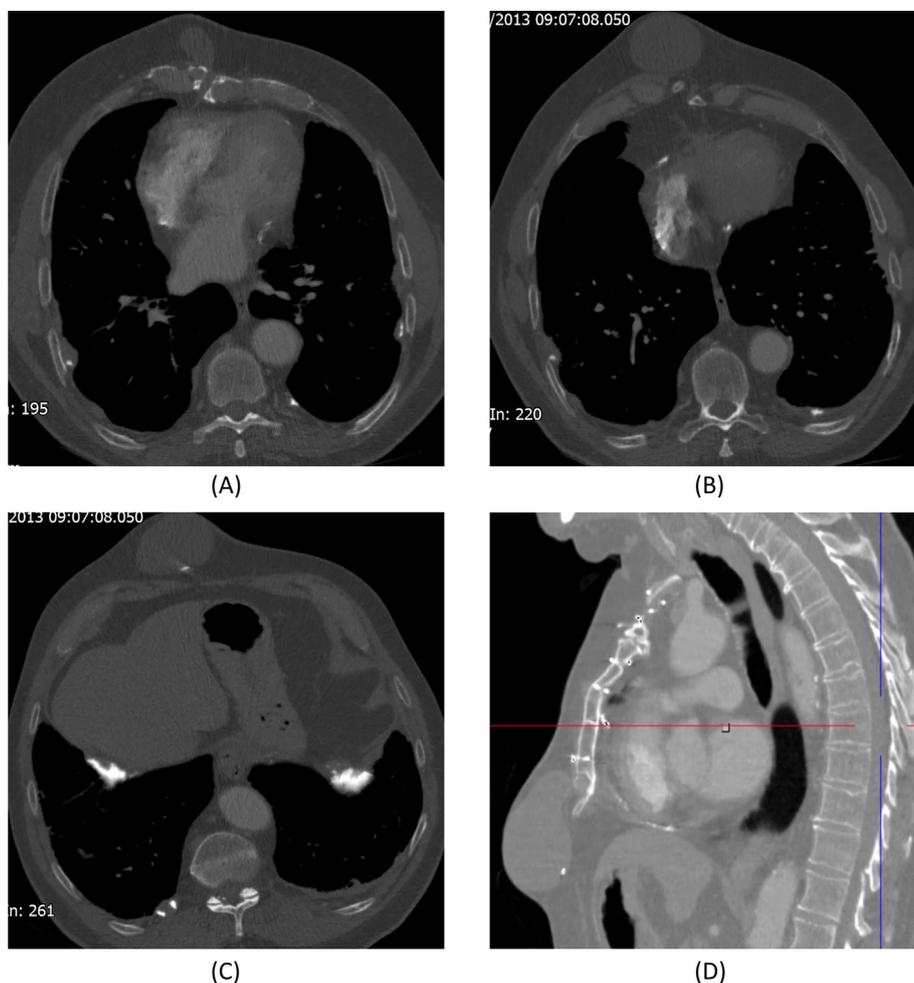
CT scan with contrast injection showed: the sternal dehiscence through which the neck of the lesion was connected to the mediastinum as well as bilateral pleural thickening and calcification (A), the cystic nature of the lesion and calcified spots at atrio-ventricular groove (B), dense diaphragmatic copulae calcifications (C), and curvi-linear pericardial calcification.
